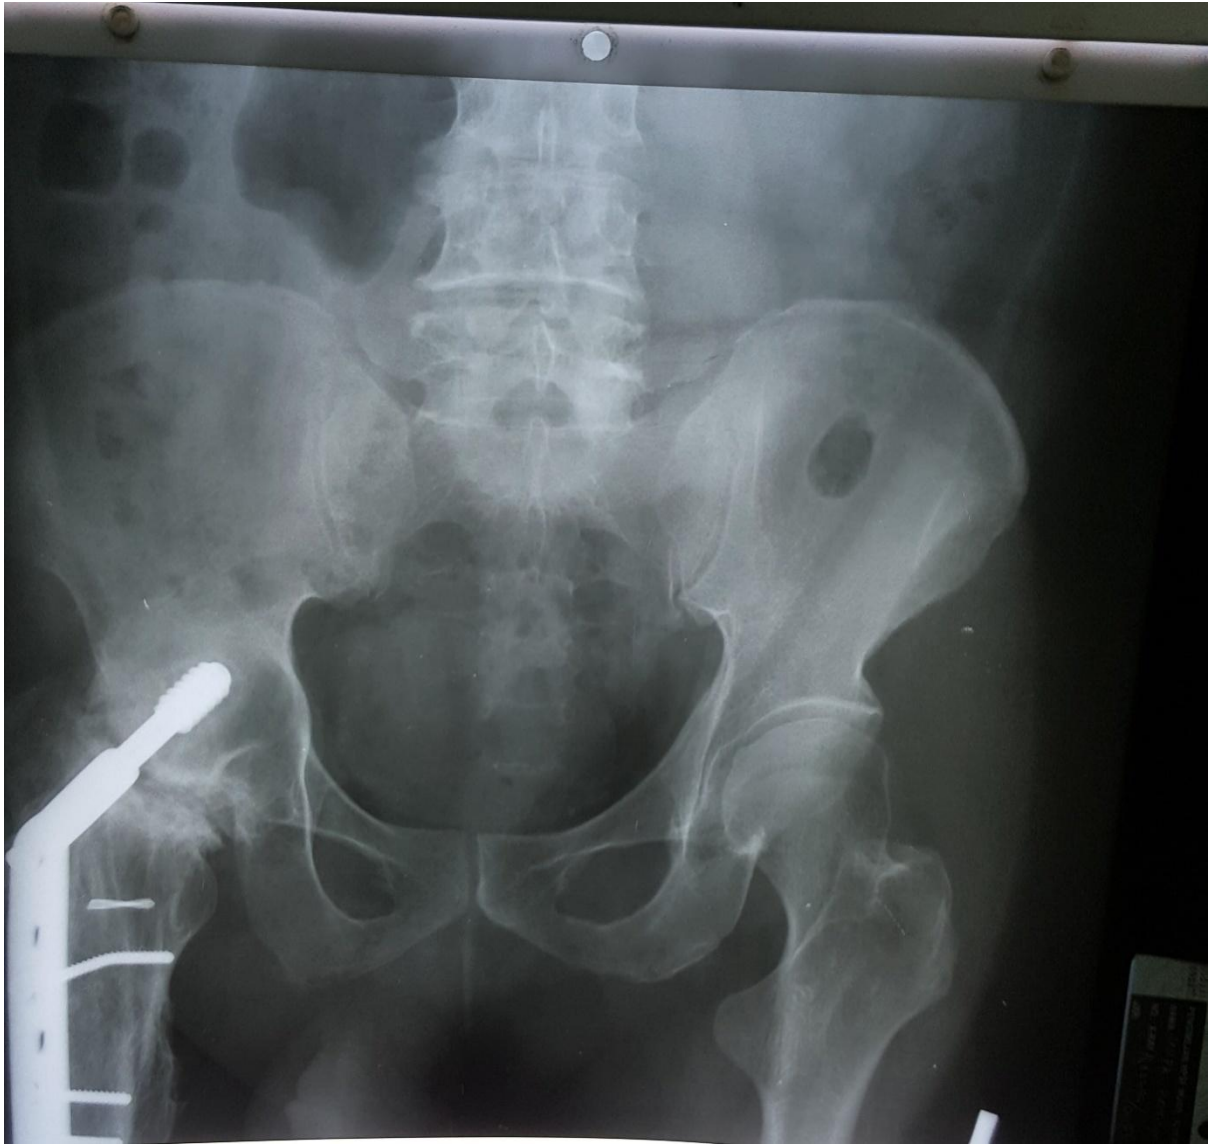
Post-operative radiograph of Pelvis and both Hip joints, Anteroposterior view (15/02/2010). Plain x ray showing “stage of arthritis”, pathology involving articular surface. Irregular and hazy joint margins with diminished joint space on the right side.
